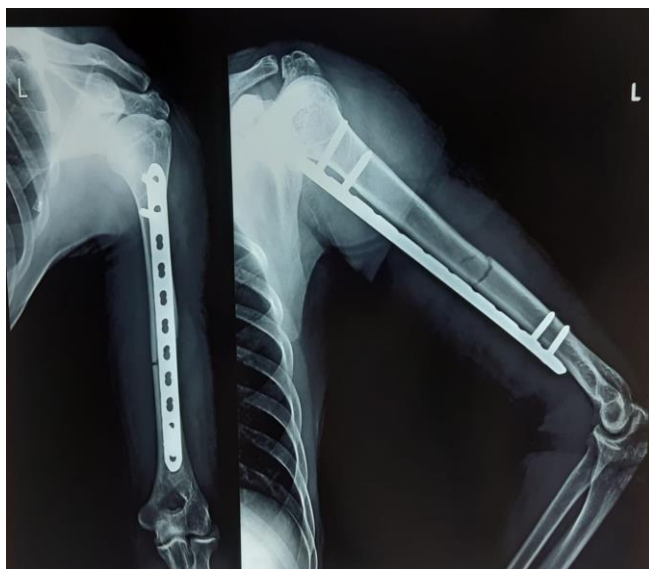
Immediate post op Xray
